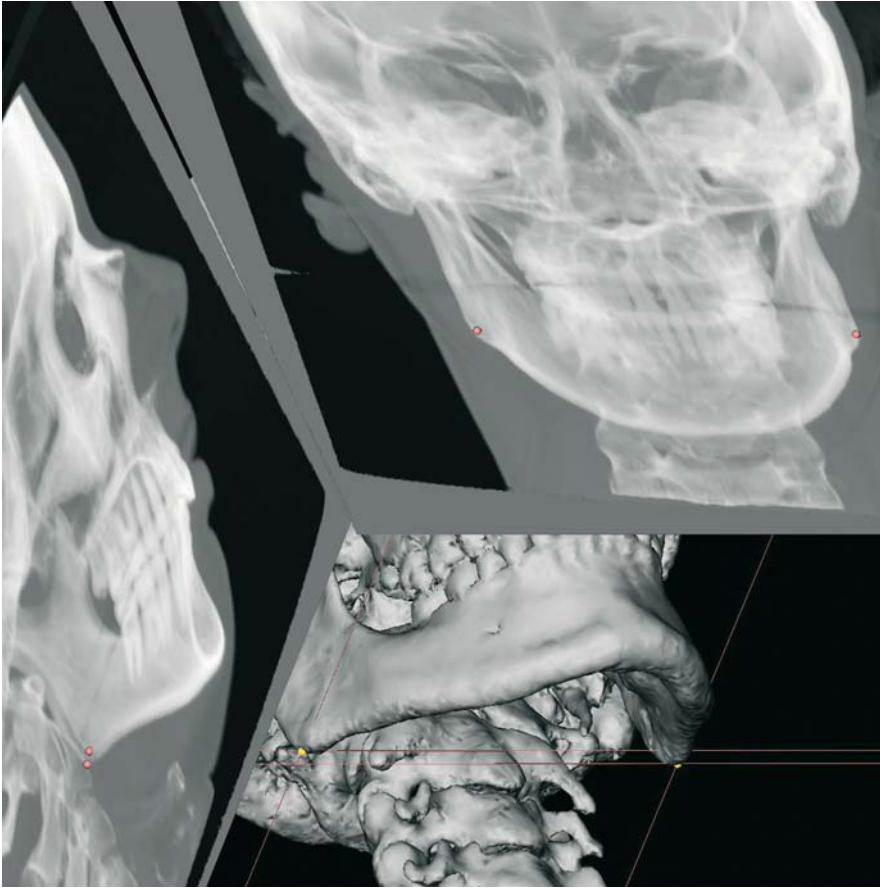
Gonion_r and Gonion_l. Virtual lateral and frontal cephalograms linked to the 3-D hard tissue surface representation (3-D CT, patient K.C.)
